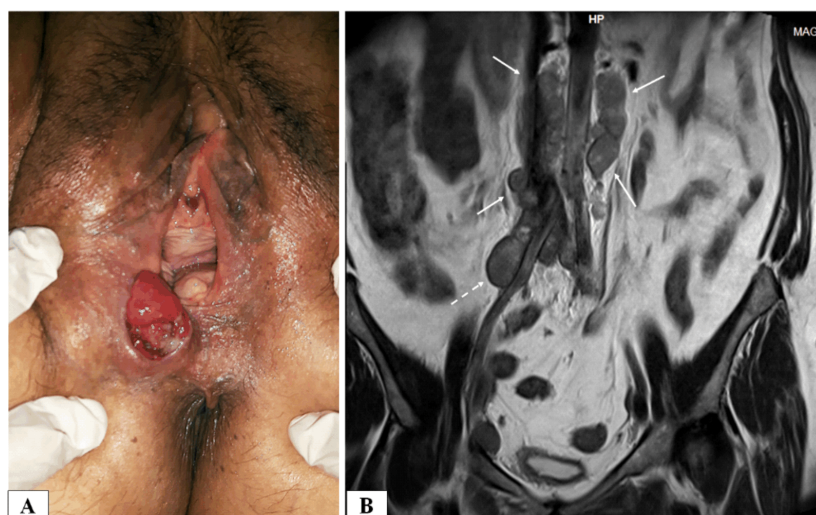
(A) Photography of the vulva, with a 1.5×2 cm tumor growing from the former Bartholin gland; (B) Coronal T2-weighted MRI exam of the lower abdomen and pelvis showing enlarged para-aortic lymph nodes (arrows) and enlarged right iliac lymph nodes (dashed arrow). MRI: Magnetic resonance imaging.
